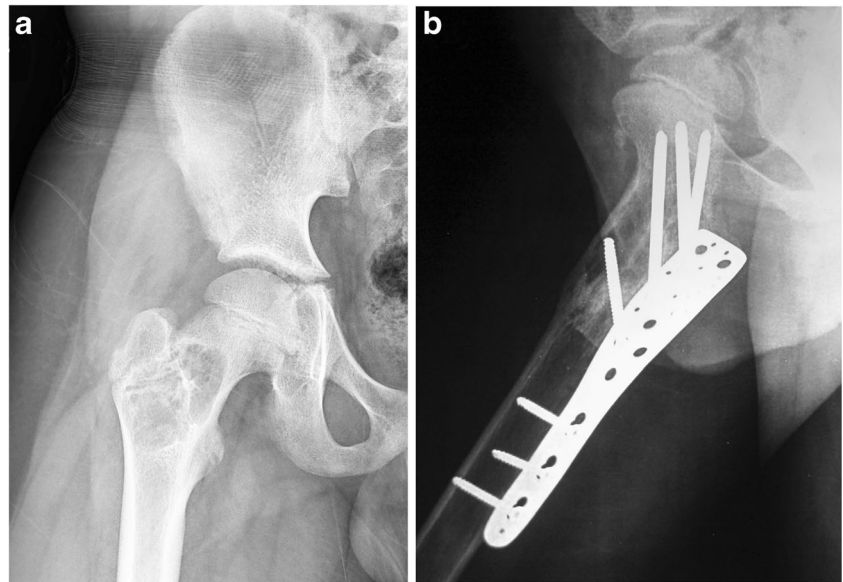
a Anteroposterior radiograph of a proximal femur of a nine year-old boy showing a simple bone cyst Dormans type IIB (case 9). b Lateral radiograph showing incomplete healing with residual radiolucency 30 months after surgery
